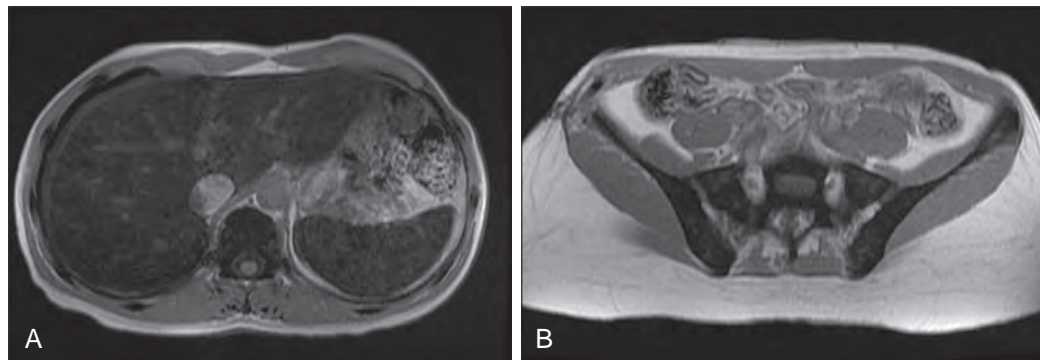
Hemosiderosis: MR findings. A. Axial T1-weighted image shows marked decrease in signal intensity of the liver and spleen due to iron deposition into the Kupffer cells of the liver and the reticuloendothelial cells of the spleen. B. Axial T1-weighted image of the pelvis in the same patient shows markedly decreased signal intensity within the pelvic bones due to the deposition of iron into bone marrow reticuloendothelial cells.
